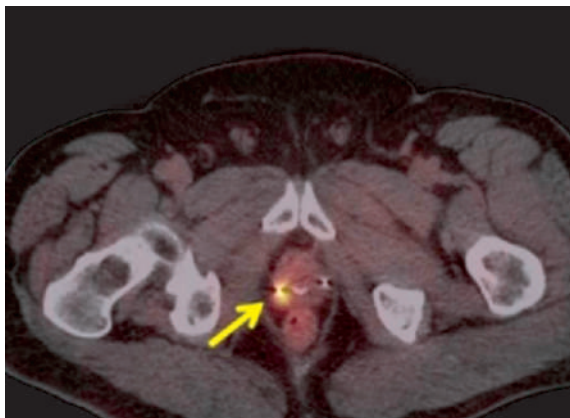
Axial PET / CT showing increased uptake in the right side of the prostate gland (Yellow arrow).
